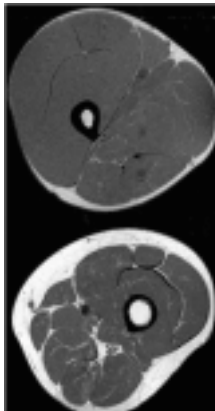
Typical T1-weighted ^1H MR images recorded on a Siemens Vision Plus system (extremity coil) representing transverse sections of the thigh recorded at rest in a professional cyclist (A) and an age and sex-matched control subject.
